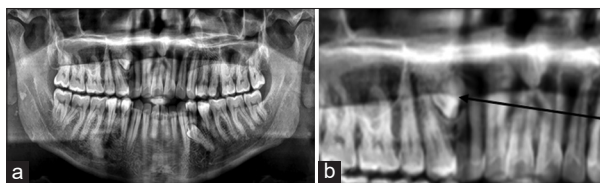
(a) Orthopantomogram (OPG); (b) OPG showing odontome (case 6)
